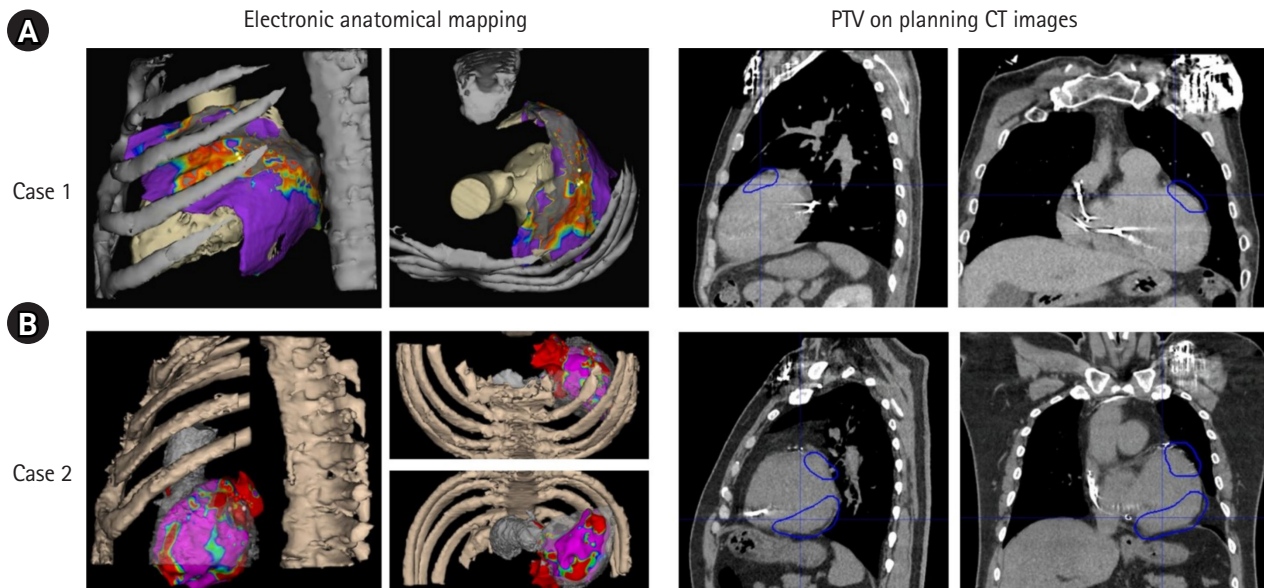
Target volume delineation (right column) with reference to the regions activated in electronic anatomical mapping for two cases: (A) case 1 and (B) case B. PTV, planning target volume; CT, computed tomography.
